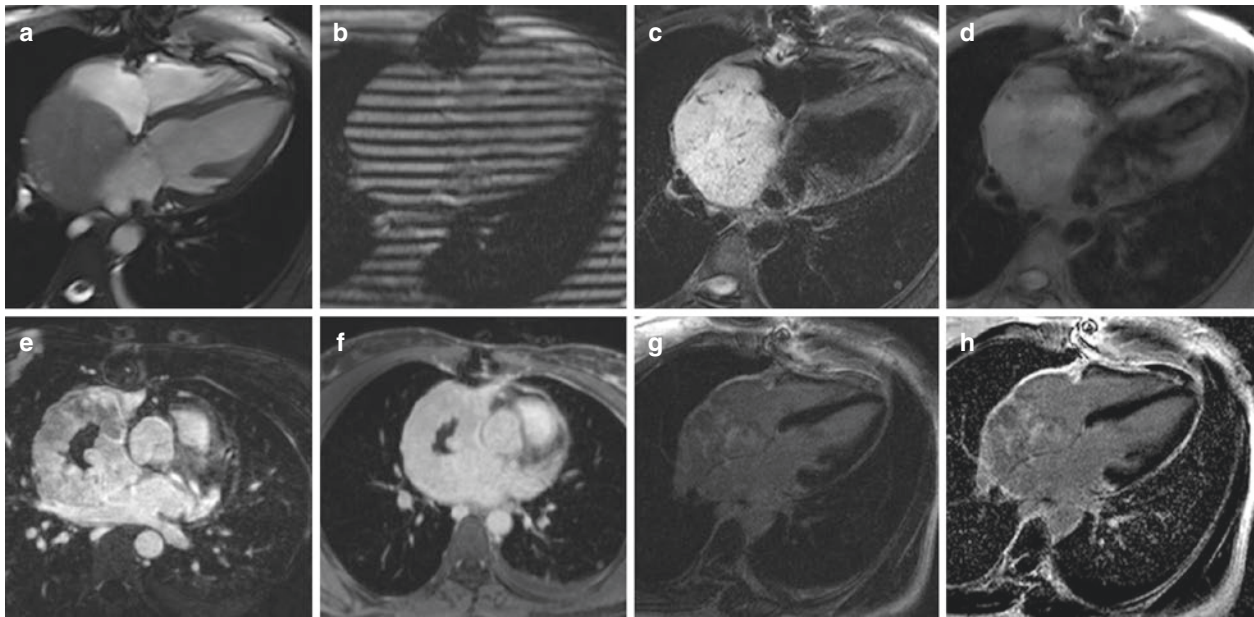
(a–h) Four-chamber SSFP still frame reveals a large mass encroaching upon the right and left atria (a); the same view (b) with tag lines indicate the mass is malignant and infiltrating as evidenced by no line break in the moving file (see separate movie file); T2- and T1-weighted images (c, d, respectively) indicate that the mass is hyperintense on T2 with a central scar; a still frame from a navigator sequence in (e) reveals central necrosis in the mass (central black area). A navigator sequence was very helpful in this case to determine the extent of the mass. It revealed a $7.9 \times 5.1 \times 5.7$ cm (AP \times trans \times CC) mass, centered immediately superior to the right atrium. The mass was seen to invade the superior right atrial wall, extending into the right atrial lumen inferiorly. Anteriorly, the mass invaded into the SVC, completely obliterating
